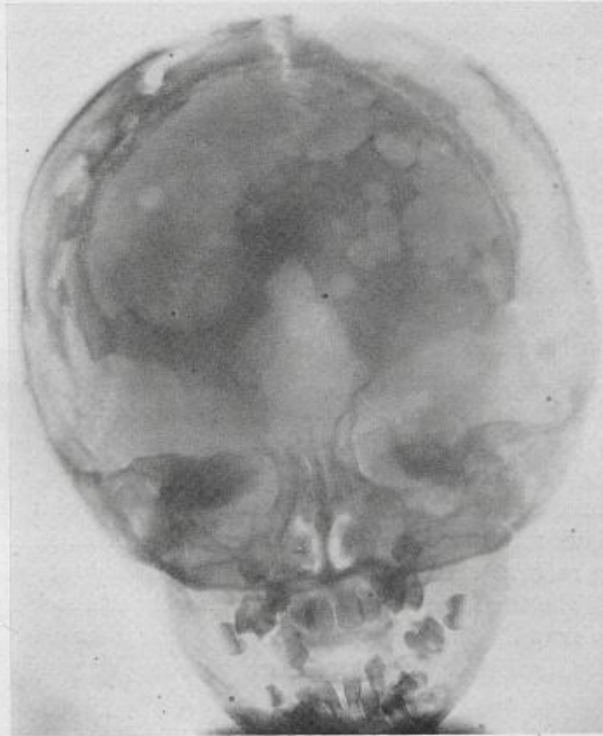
x-Ray of skull showing bone defects: frontal view.
